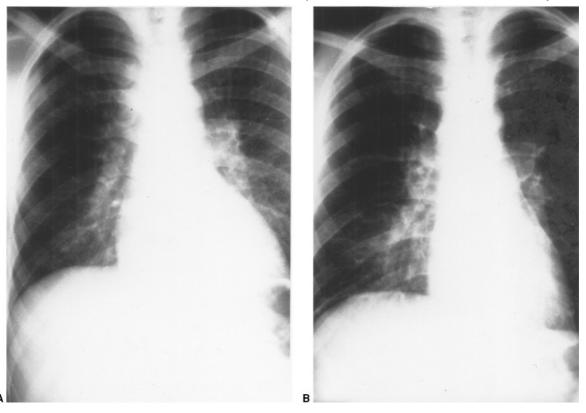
A: Chest radiograph in a patient with tuberculosis and HIV infection. There is right paratracheal adenopathy (arrow) with clear lung elds. Sputum culture was positive for *M. tuberculosis*. B: The radiograph abnormality resolved (as did the patient's symptoms) following several months of antituberculosis drug treatment. (From ref. 1, with permission.)
